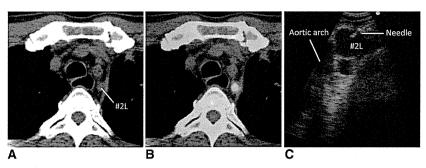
Transesophageal endoscopic ultrasound-guided fine needle aspiration for the left upper paratracheal lymph node (no. 2L), which provided the only diagnosis of N2 disease (squamous cell carcinoma). A, Computed tomography image. B, Positron emission tomography-computed tomography image. C, Transesophageal endoscopic ultrasound image.
